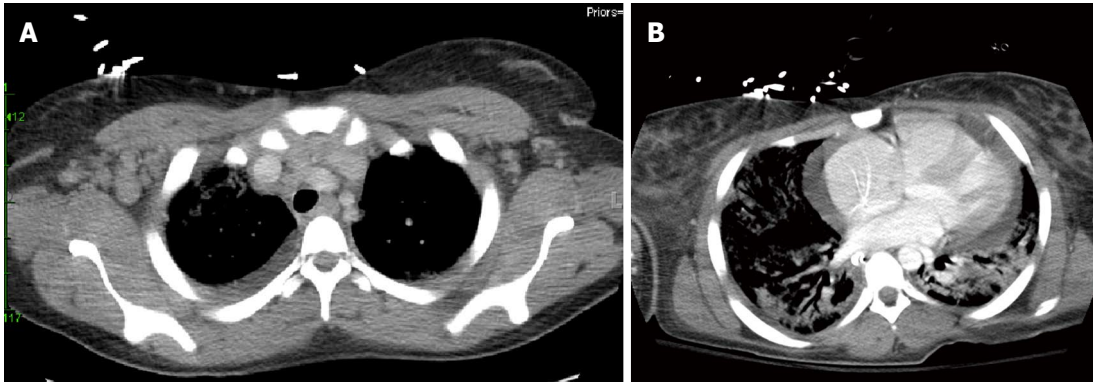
Computerized tomography chest. A: Computerized tomography (CT) chest demonstrating significant axillary lymphadenopathy; B: CT chest revealing bilateral lung consolidation, and a moderate pericardial effusion.
